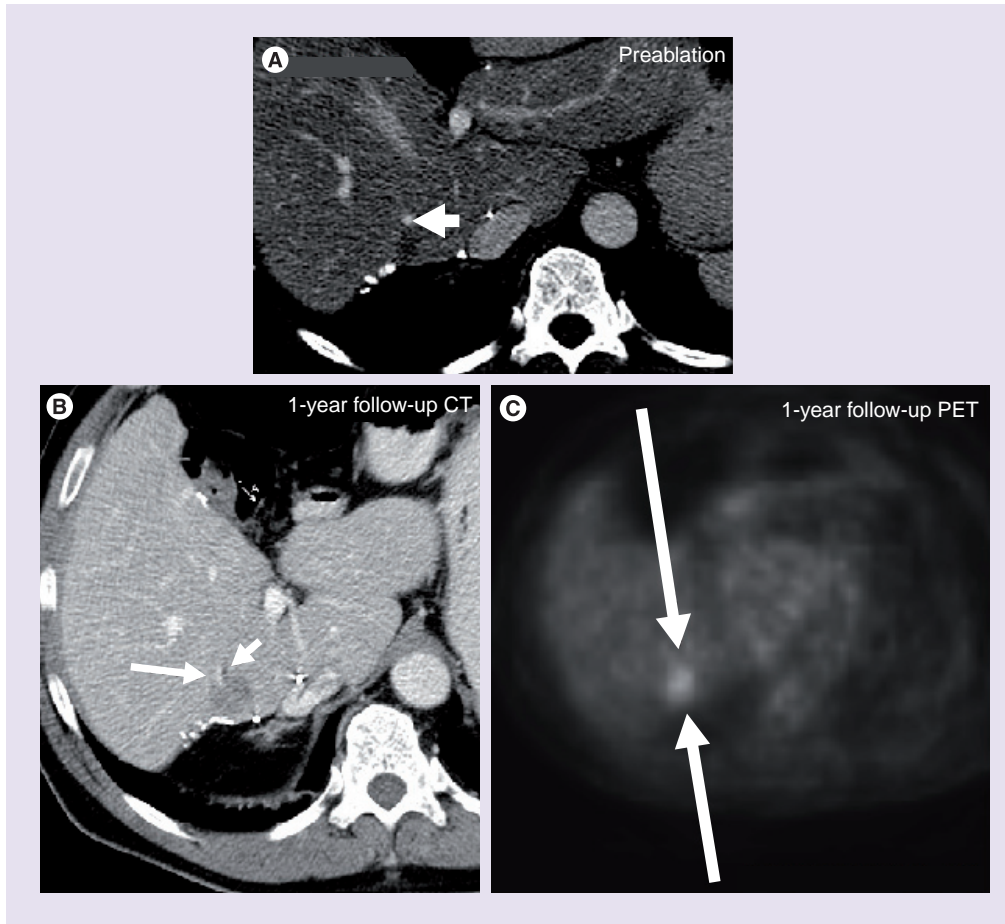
Heat sink effect. (A) Contrast-enhanced CT demonstrating a low-density region adjacent to surgical clips in the right hepatic lobe compatible with local tumor recurrence. Note the vessel (white arrow) along the deeper margin. (B) Contrast-enhanced CT and (C) PET demonstrating tumor recurrence adjacent to the vessel (arrows).
